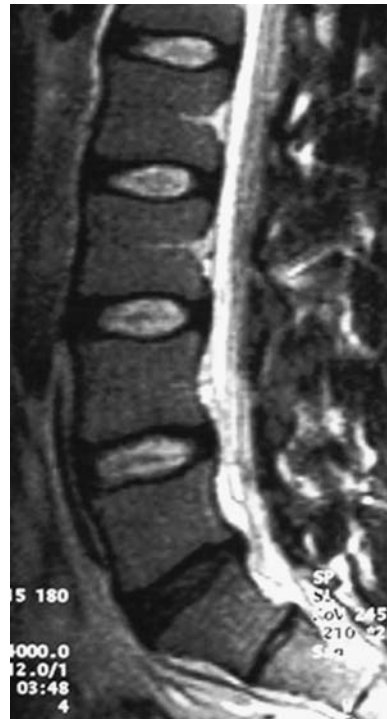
Sagittal T2-weighted magnetic resonance image of the lumbar spine demonstrating an L5–S1 “black disc.”
